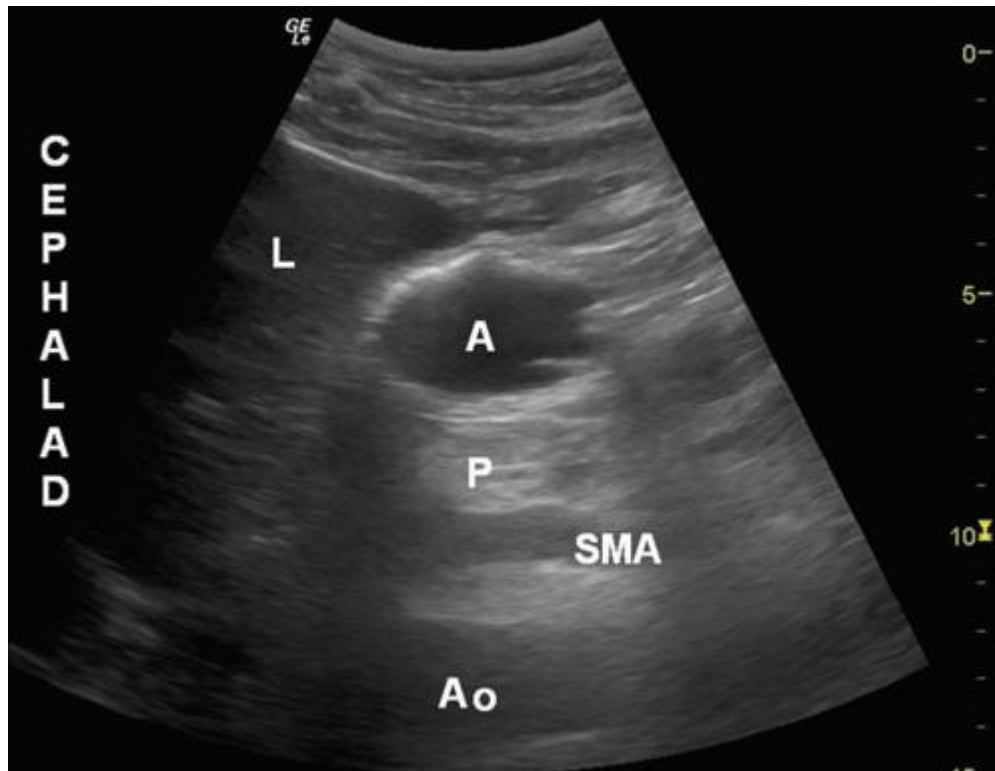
Sonographic image of the gastric antrum containing clear fluid. Note the antrum appears distended with hypoechoic/anechoic content. A, antrum; L, liver; P, Pancreas; Ao, Aorta; SMA, superior mesenteric artery
